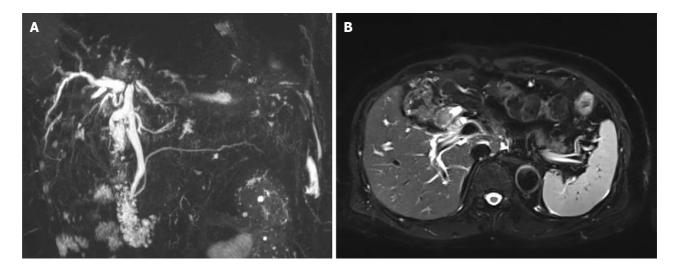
Admission magnetic resonance cholangiopancreatography and magnetic resonance imaging. A: Magnetic resonance cholangiopancreatography revealed a narrowing of the right hepatic duct at the porta hepatis; B: The spleen is morphologically normal with a homogeneous parenchymal signal.
